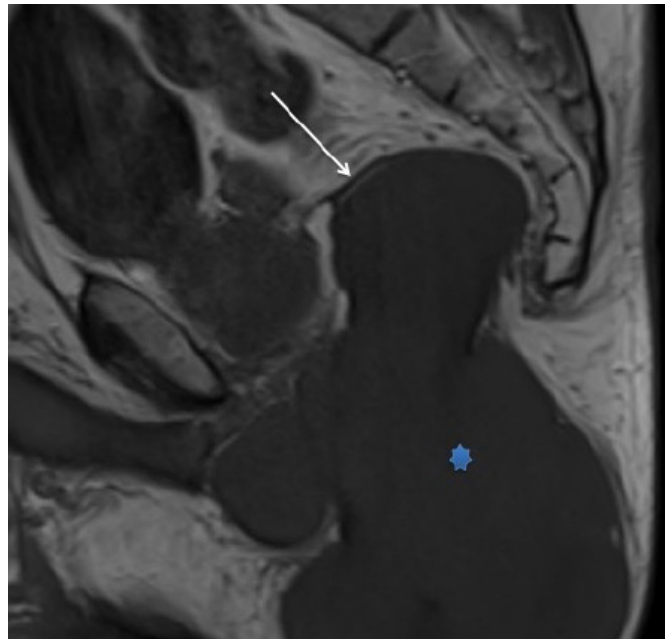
Sagittal Nonfat-Suppressed T1-Weighted MRI. Published with Permission
